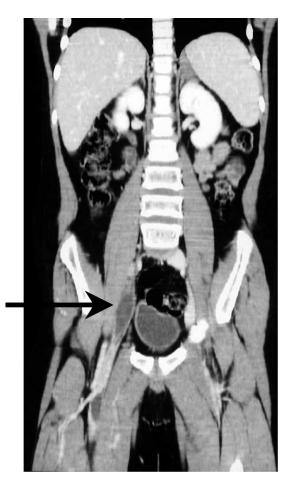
Coronal CT venography image showing a filling defect within the right iliac vein caused by a deep vein thrombosis.
